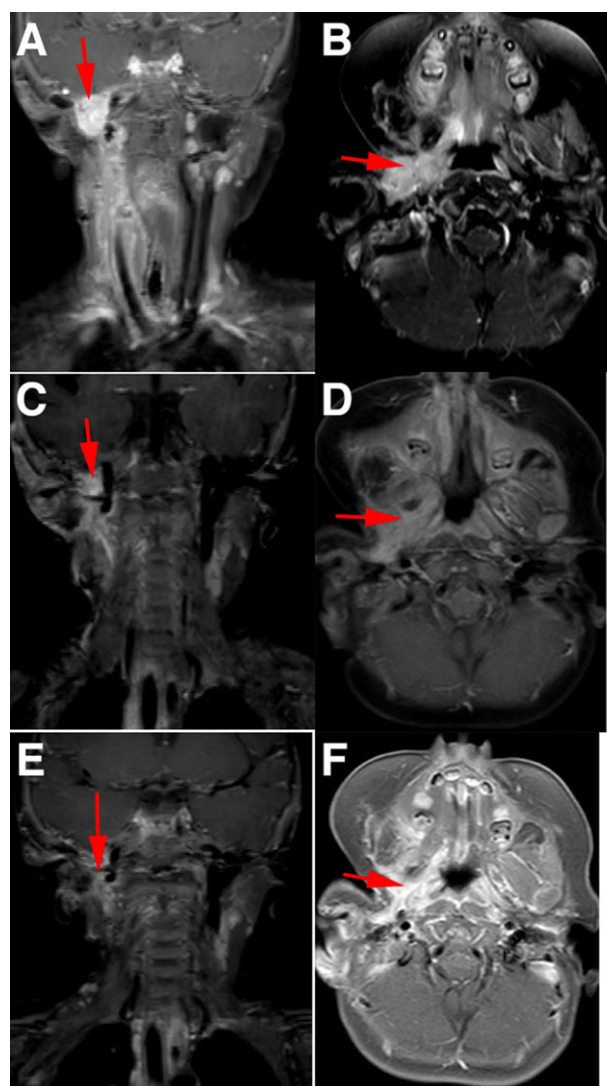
Magnetic resonance imaging (MRI) of baseline disease assessment of the (A) neck and (B) oral cavity, with areas of interested highlighted with red arrows. Magnetic resonance imaging demonstrating >90% reduction in tumor masses of the (C) neck and (D) oral cavity following completion of the first month of therapy. Confirmation of the tumor response and decreased enhancement demonstrated by MRI of the (E) neck and (F) oral cavity following the second month of therapy.
